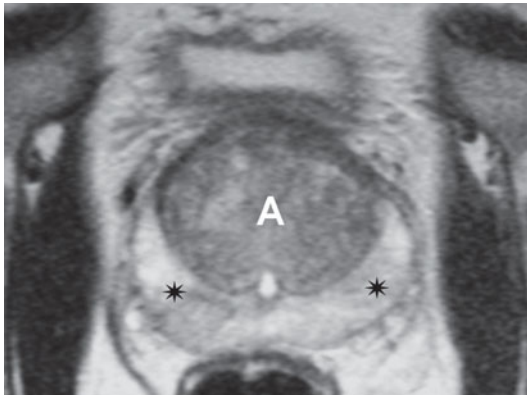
Magnetic resonance. Prostate. Elderly male. Study performed with intracavitary coil. T2-weighted axial sequence. In the centre of the gland an adenoma can be identified (A). The *asterisks* indicate the peripheral zone
